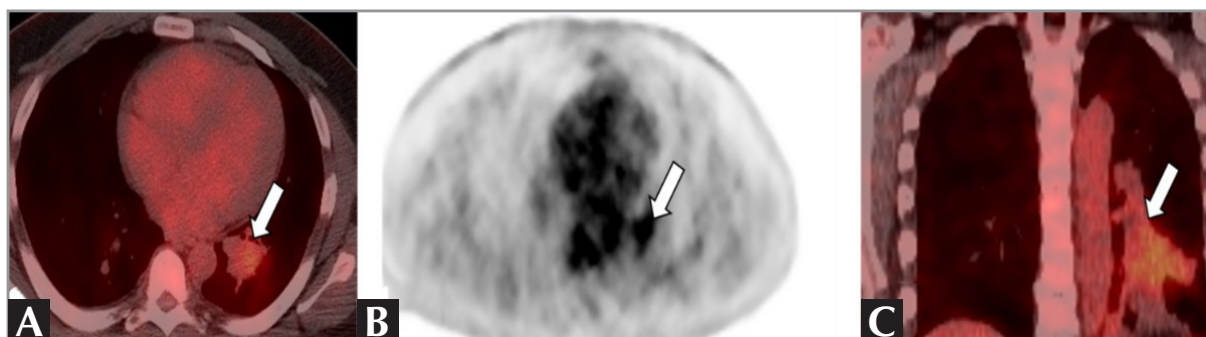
(A-C). Axial PET-CT images show mild FDG uptake within the nodule (arrows) and post-obstructive pneumonia.
